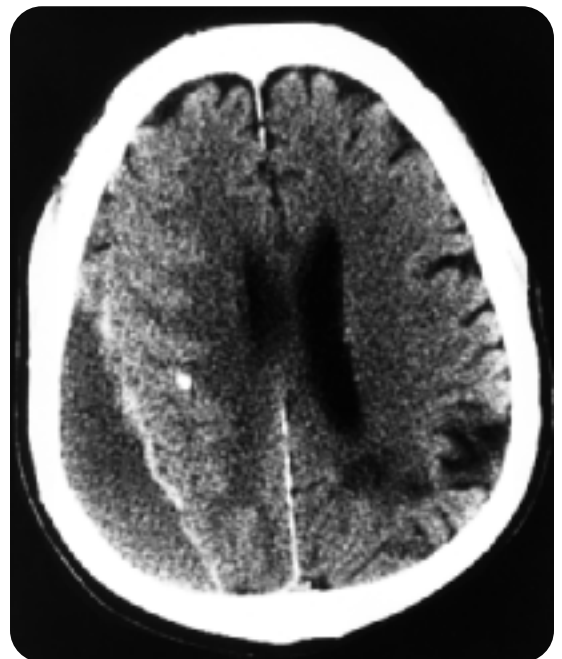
Computed tomography. A male patient reported increased sleepiness and a change in personality 3 weeks after falling and striking his head. The cranial computed tomographic scan demonstrates a chronic subdural hematoma.
